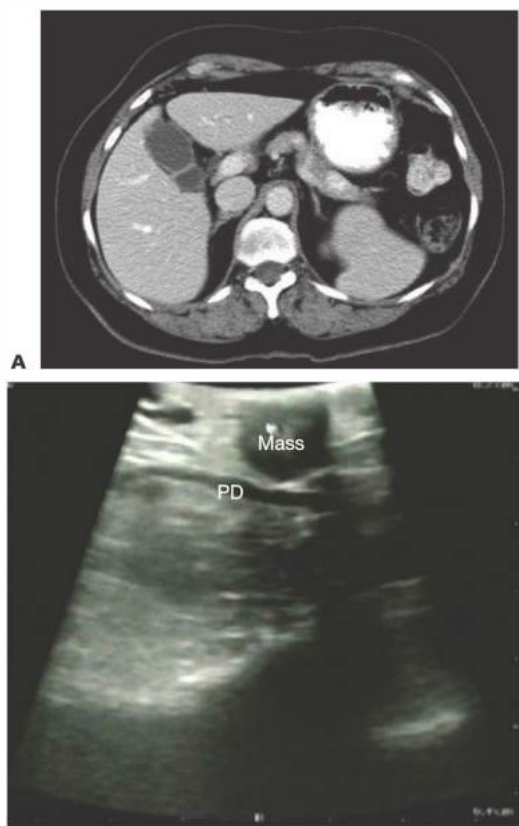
• A. Venous-phase CT showing a rounded hypervascular mass in the pancreatic tail. The patient presented with symptomatic hypoglycemia. The tumor was proven to be an insulinoma by EUS/FNA. She was treated with a spleen-preserving distal pancreatectomy. B. IOUS showing the insulinoma at the time of resection. The deep margin was within 2 mm of the pancreatic duct (PD).
